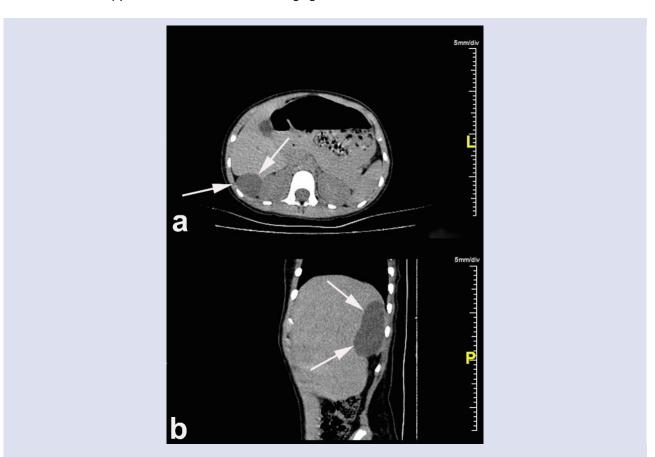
Pretreatment axial (a) and sagittal reformatted (b) computed tomography images show diaphragmatic mesothelial cyst (arrows).
